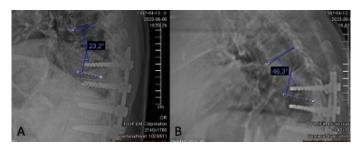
A) Supine x-ray RKA of 23.2° and B) Standing x-ray RKA of 46.3°.
